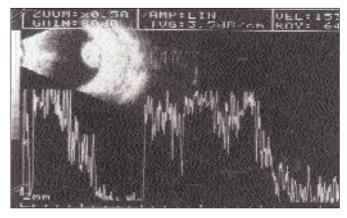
A- and B-scan ultrasonograpy of the largest choroidal tumor.
